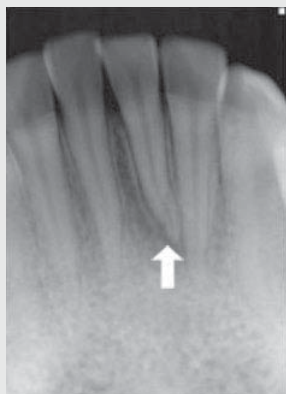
periapical x-ray(7 months after curettage): reduced radiolucency and intact lamina dura
